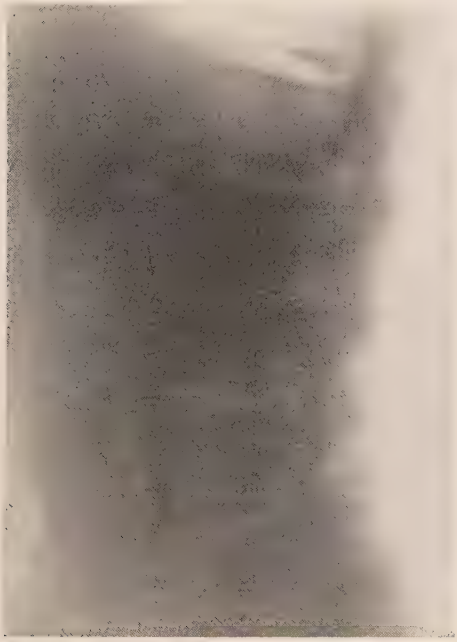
Crushing fracture of third lumbar vertebra. (Roentgenogram by Dr. G. C. Bird.)
